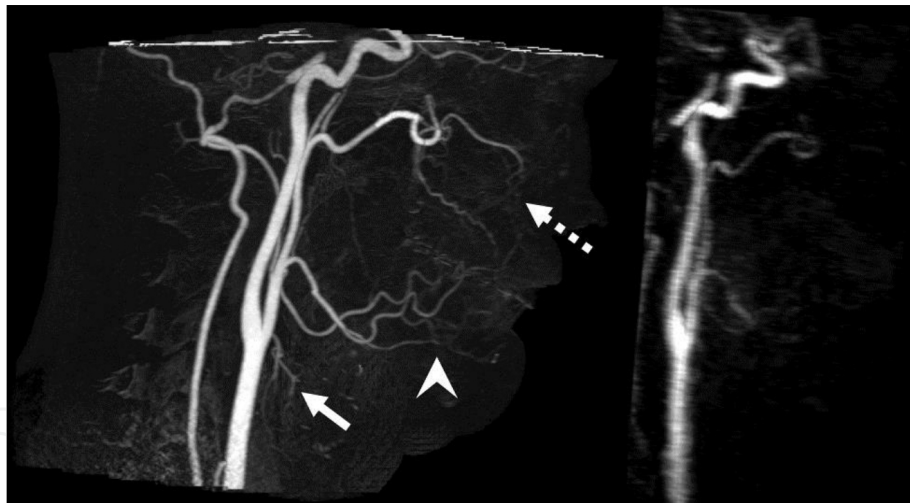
CT angiogram (left) demonstrating fine anatomical outline of internal maxillary, lingual and superior thyroid arteries in contrast to MR angiography which offers less resolution (right). Image reproduced from Shigeyoshi et al. [15].
